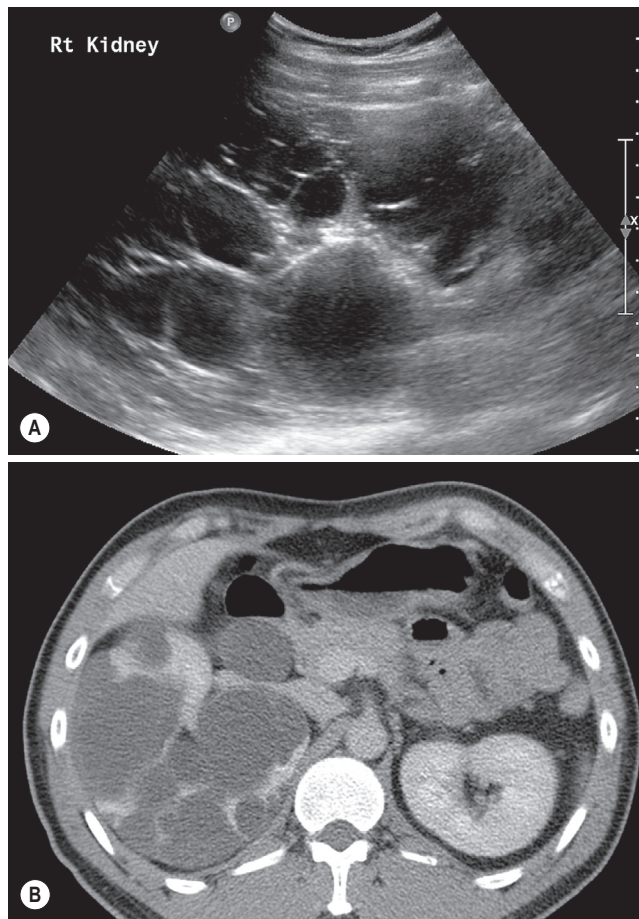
■ Localised cystic kidney disease. Ultrasound (A) and CT (B) demonstrate multiple cysts throughout both kidneys with no solid elements. The initial US was interpreted as a probable multicystic dysplastic kidney (contralateral kidney was normal), although the CT demonstrates the presence of some normal renal parenchyma surrounding the kidney in keeping with localised cystic kidney disease.
